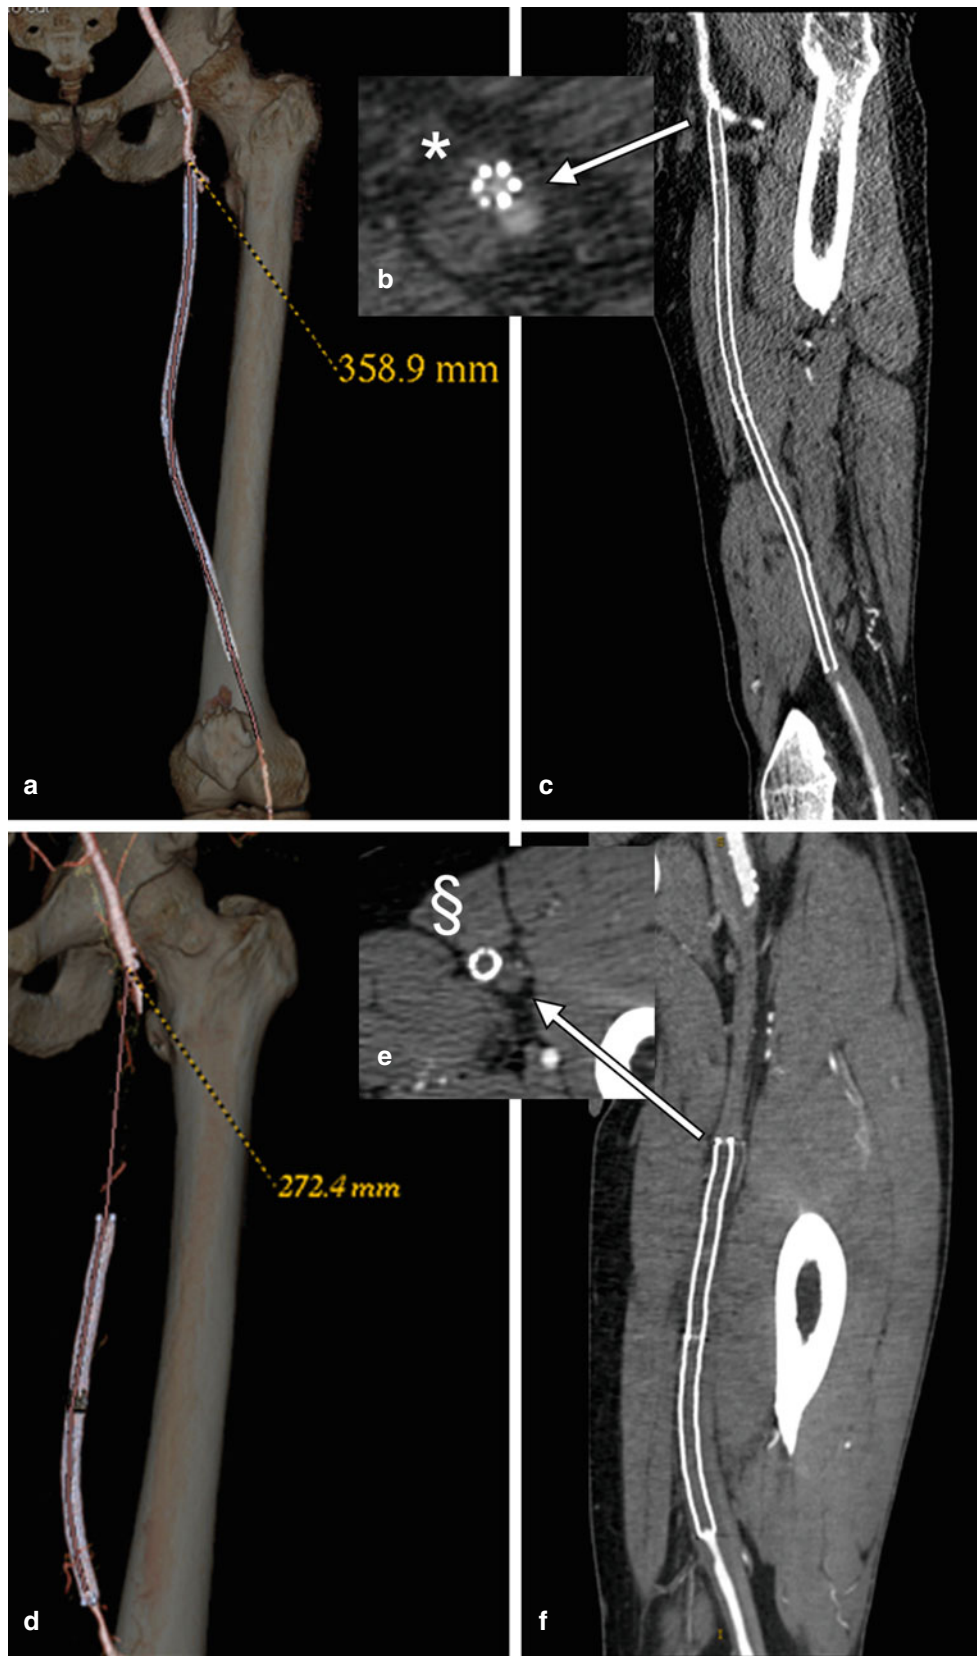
Preprocedural computed tomography angiography with volume rendering (a, d), curved (c, f) and axial view (b, e) showing an example of intraluminal occluded femoral stent (*) (a-c) and a subintimal occluded femoral stent (§) (d-f)
